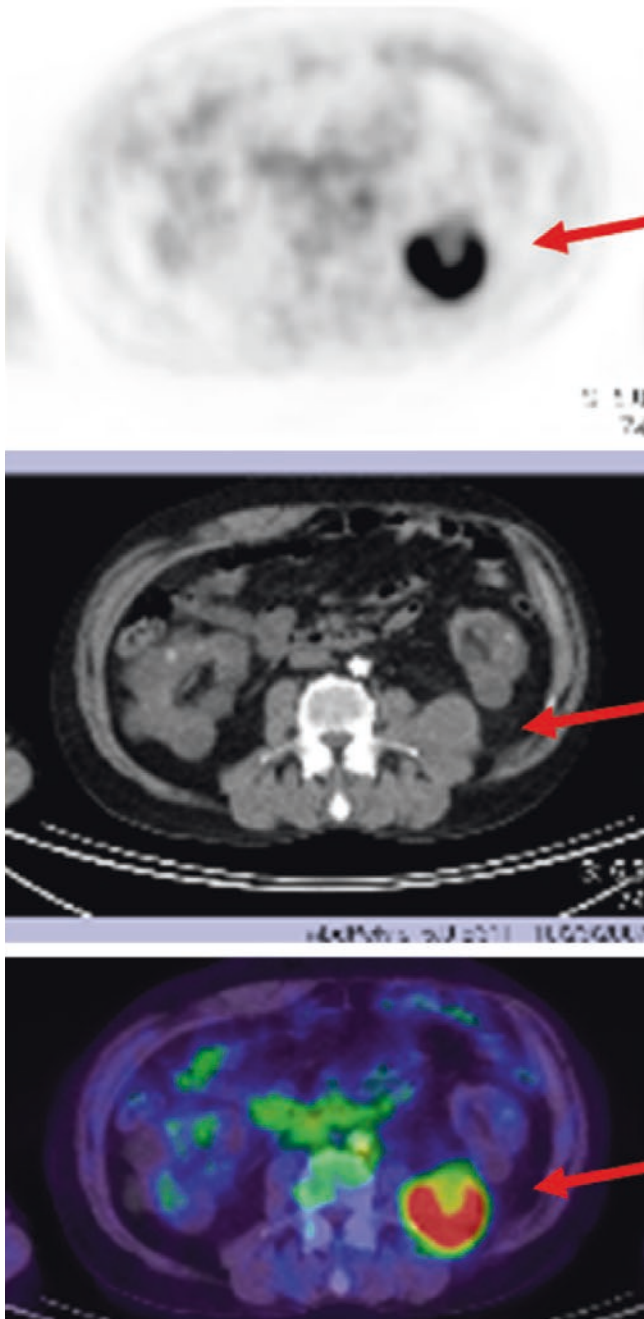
Axial images of PET, CT and fusion images of PET/CT from top to bottom. Please note the left kidney locating anterior to the FDG avid aortic graft, having no FDG uptake due to the renal failure. Arrows indicated the lesion
